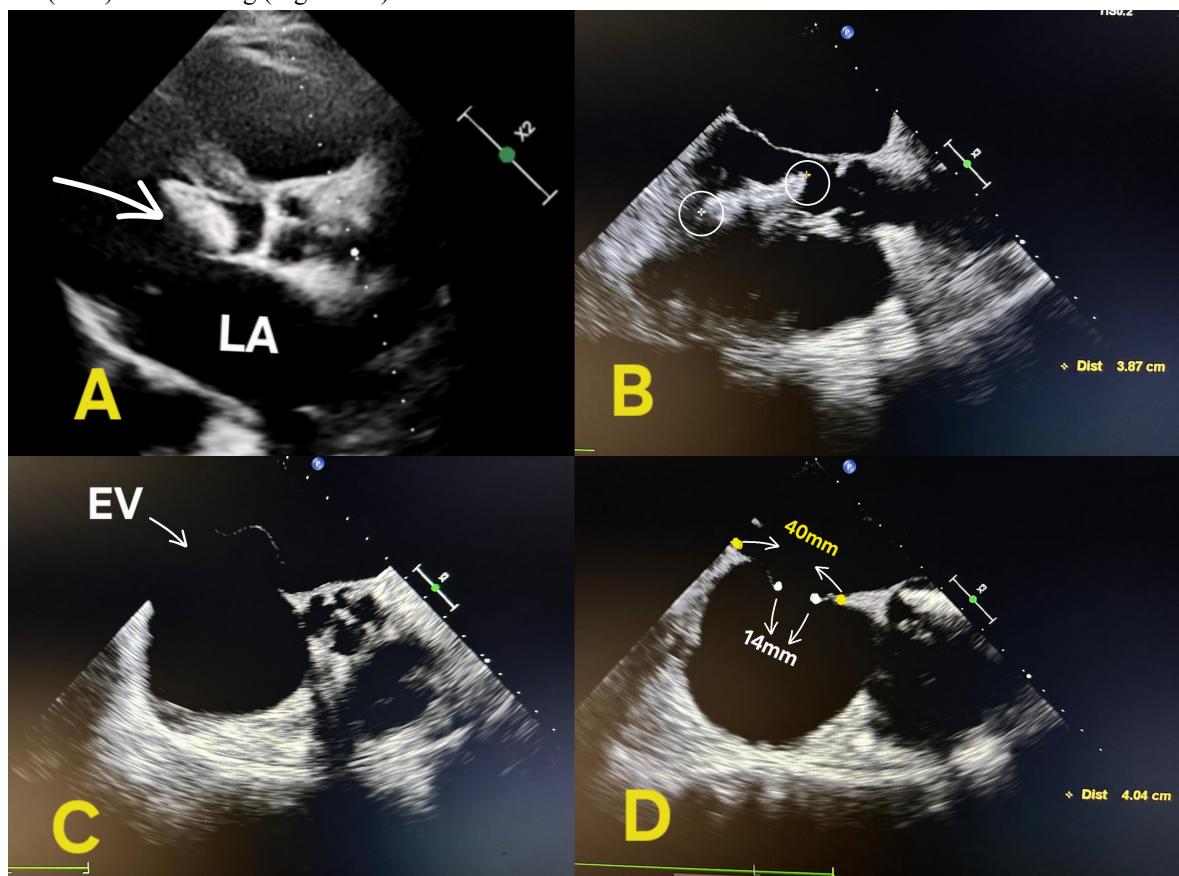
Preoperative transthoracic (A) and transesophageal echocardiographic images of 38 mm measured embolized device (arrow) in left ventricular outflow (B), long flail EV (arrow) bulging to left atrium (C) seems like superior atrial septum that may cause misinterpretation of defect size as 14 mm instead of 40 mm where there's no posterior rim (D). LA = left atrium; RA = right atrium; EV= Eustachian valve.
